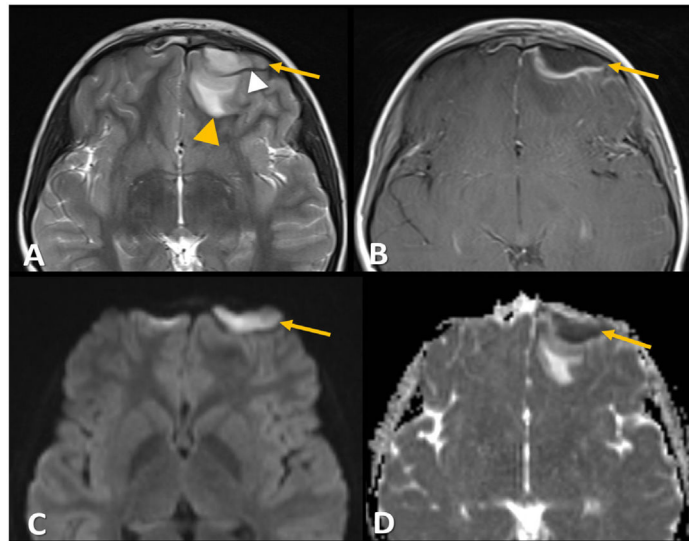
Epidural empyema: Axial T2WI (A), post-contrast T1WI (B and F), DWI (C) and ADC map (D) show two rim-enhancing extra-axial fluid collections, one with biconvex morphology, suggestive of epidural empyema (yellow arrows in A–D). Note the hypointense rim at the interface with the brain in epidural empyema (white arrowhead), representing the displaced dura, and the marked restricted diffusion (C and D), indicative of purulent content. Cerebral edema is also seen (yellow arrowhead), probably due to mass effect.
